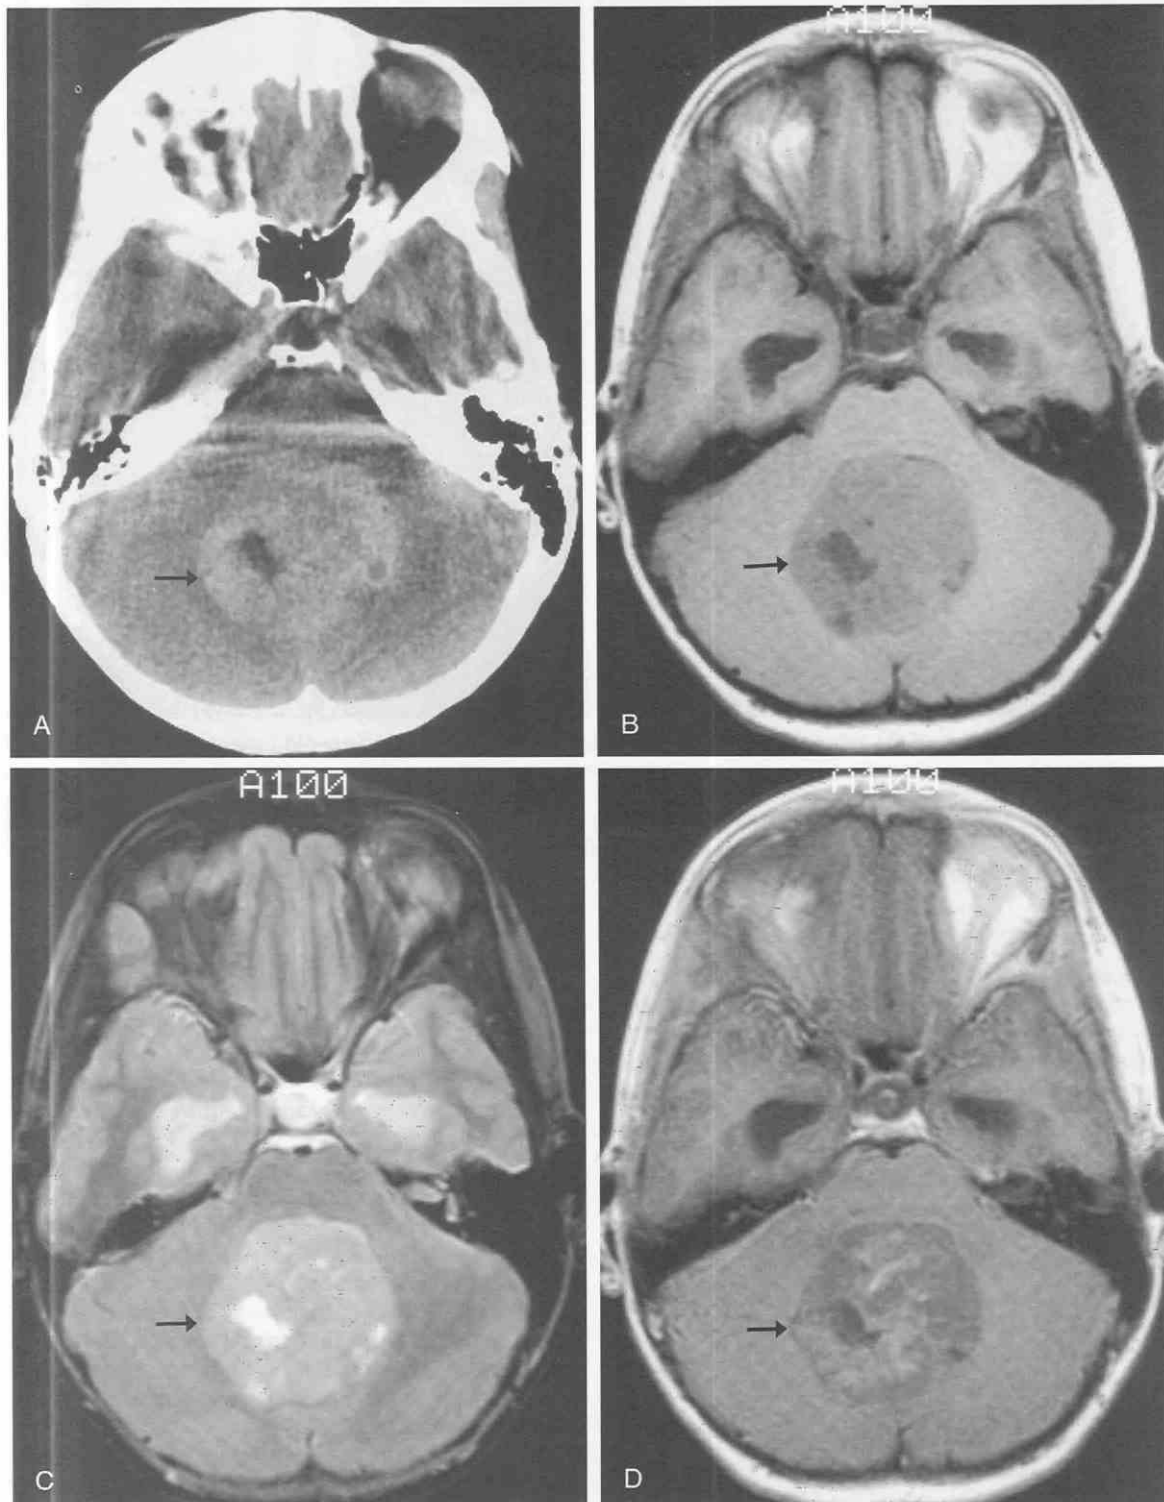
Medulloblastoma of the cerebellar vermis in an 11-year-old child. *A*, Axial noncontrast CT image demonstrates a large lobulated hyperdense round tumor (*arrow*) with an internal hypodense cavity to the right of the midline that compresses the fourth ventricle from behind. An ill defined faintly hypodense band surrounding the hyperdense mass represents white matter edema. The intratumoral area of marked hypodensity to the right of the midline likely represents necrosis. A smaller focus of lesser hypodensity on the left posterolateral tumor margin suggests an intratumoral cyst. These findings are confirmed on noncontrast axial T1-weighted (*B*) and T2-weighted (*C*) MR images; the solid portion of the tumor appears mildly hypointense on T1-weighting and mildly hyperintense on T2-weighting (*arrows*). Following intravenous gadolinium, an axial T1-weighted image (*D*) demonstrates irregular patchy contrast enhancement of the solid areas of the tumor (*arrow*).
